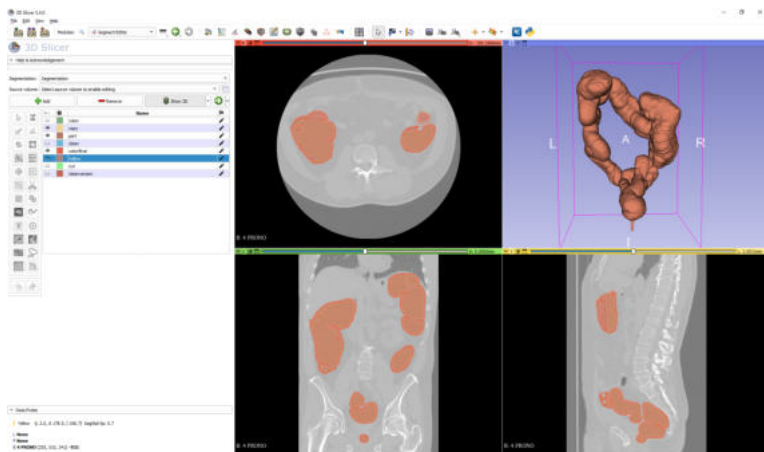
3D geometry of the colon obtained from a CT-scan. Axial, coronal, and sagittal directions are represented respectively by the red, green, and yellow windows, and the last window is a 3D view.
